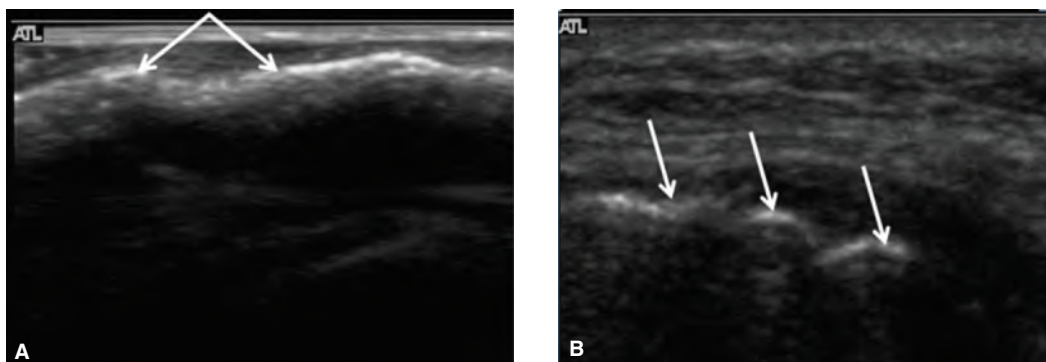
4 A. Ultrasound image of the profile of the maxilla (arrows); the image shows a “hyperechoic” area (white) where total reflection occurs. B. Ultrasound image of the maxilla that shows the contours of three roots of teeth (arrows); the contours are hyperechoic (white).
